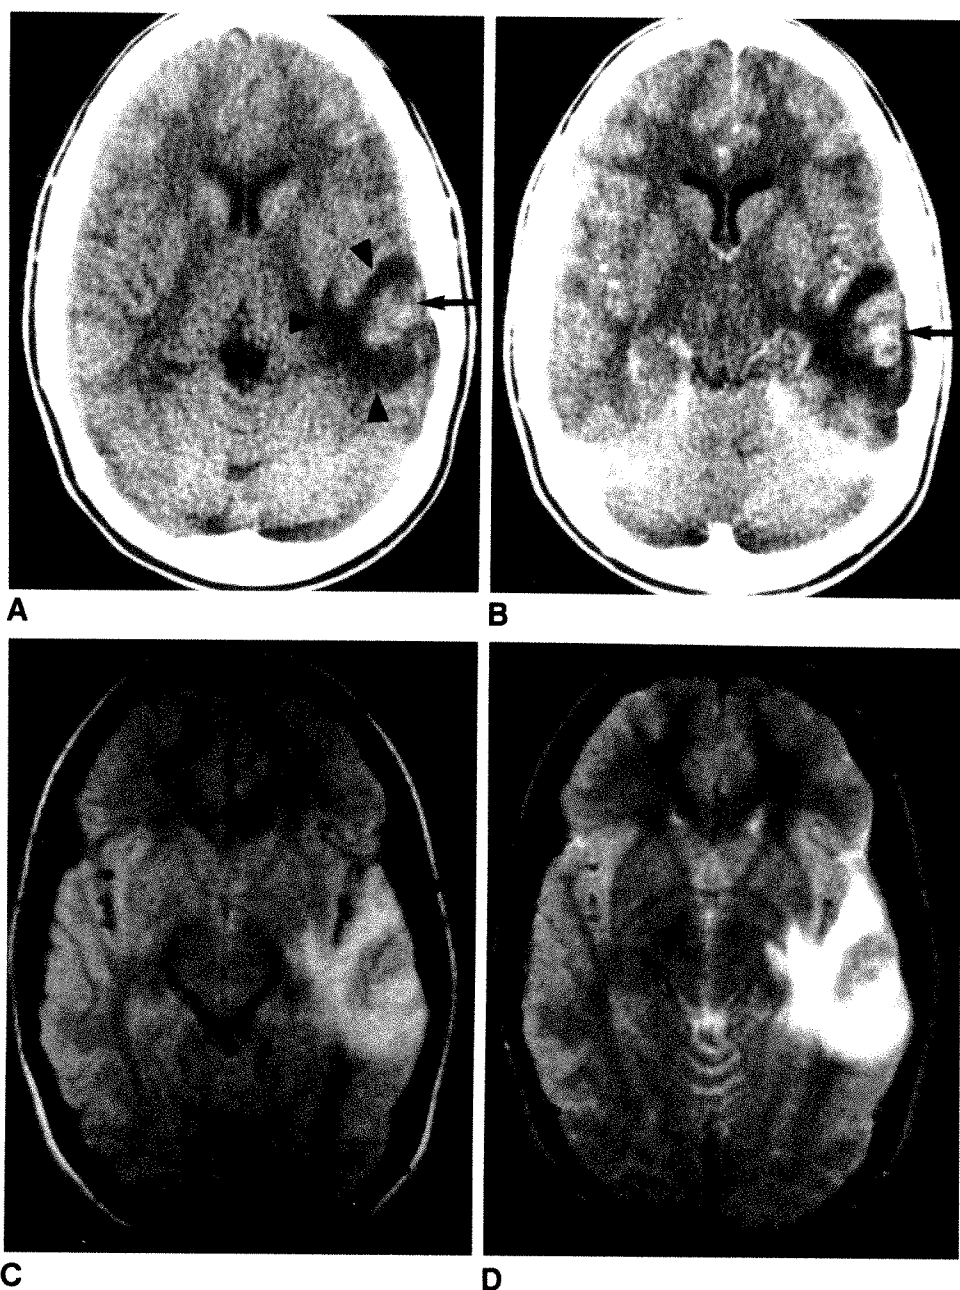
CT and MR findings in patient with seizures.
